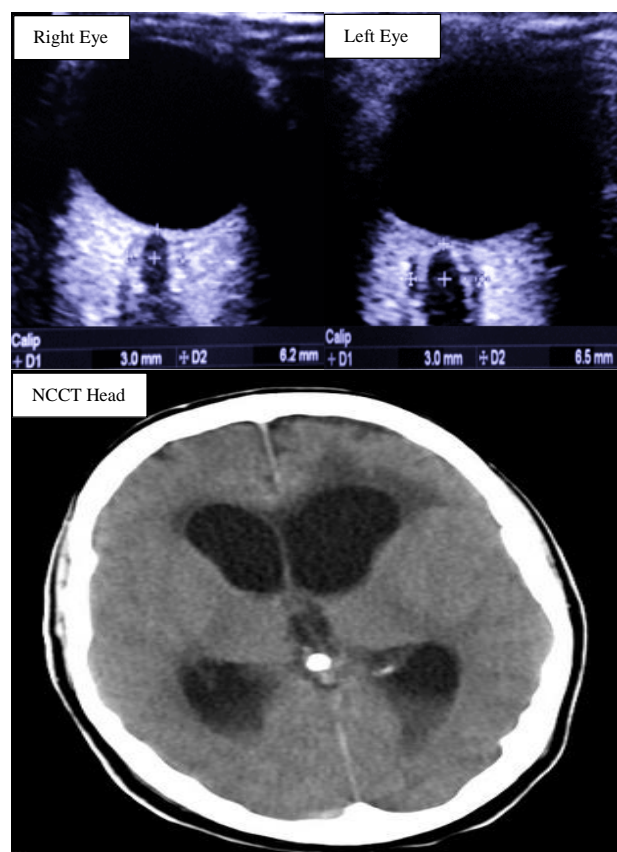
63-year-old male with altered sensorium - B scan ultrasound with measurement performed 3 mm (D1) behind vitreoretinal interface for the ONSD (D2)- ONSD measures 6.2 mm on right and 6.5 mm on left side. The average ONSD of both the eyes measures 6.35 mm which correlated with a head CT scan showing dilatation of bilateral lateral ventricles.
